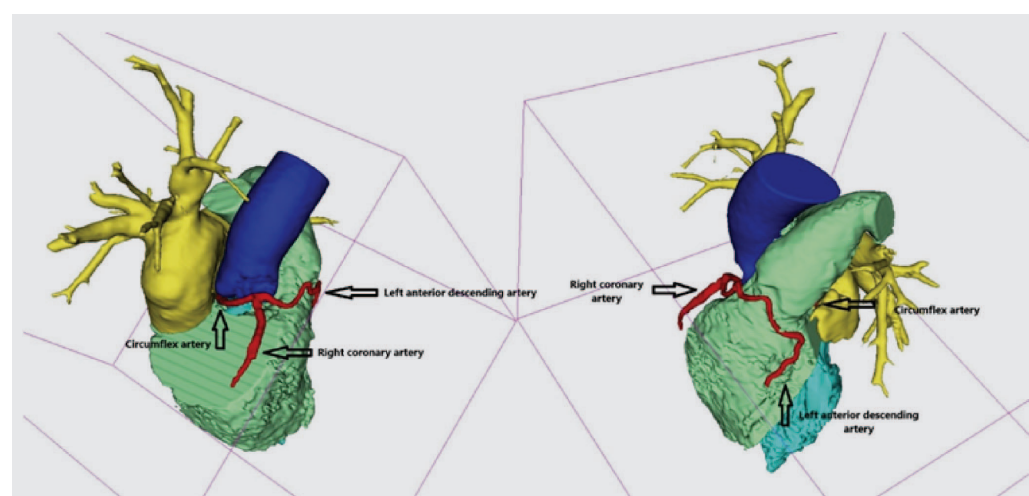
Computed tomography reconstruction demonstrating the anomalous flow of the coronary arteries.
